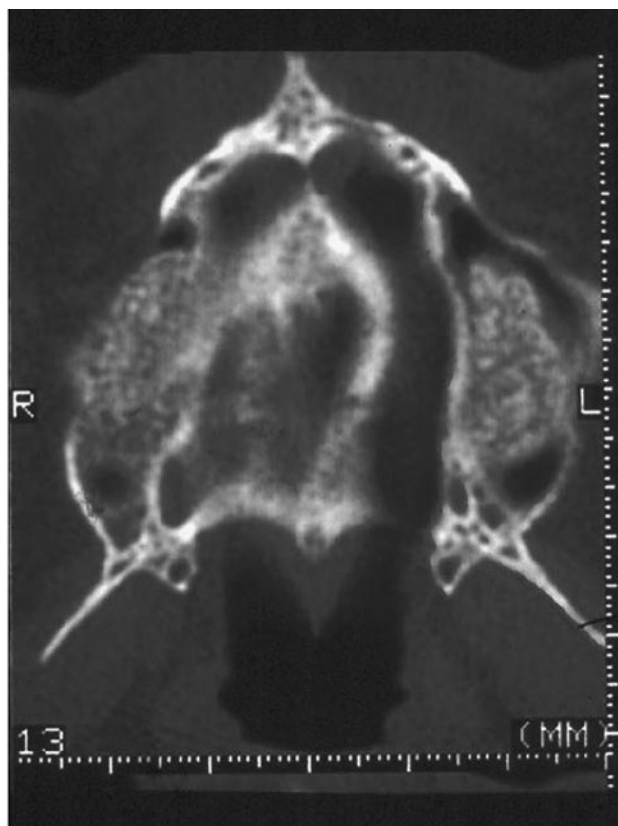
Eight months after sinus augmentation therapy utilizing Bio-Oss graft material, radiographic evidence of significant bone regeneration is noted in the created subantral space.
